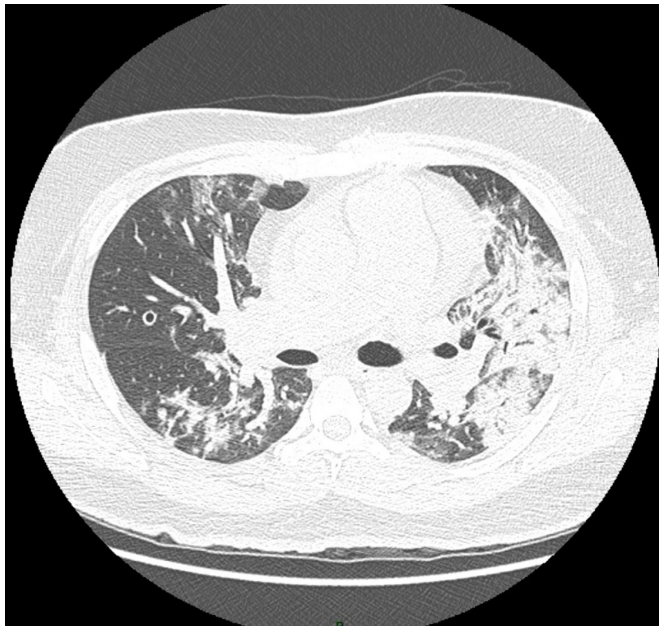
Admission CT scan.
